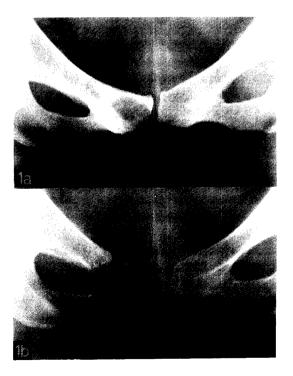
Patient 1, Chondrosarcoma. (a) Plain radiograph at the time of initial consultation. (b) post operative plain radiograph.
